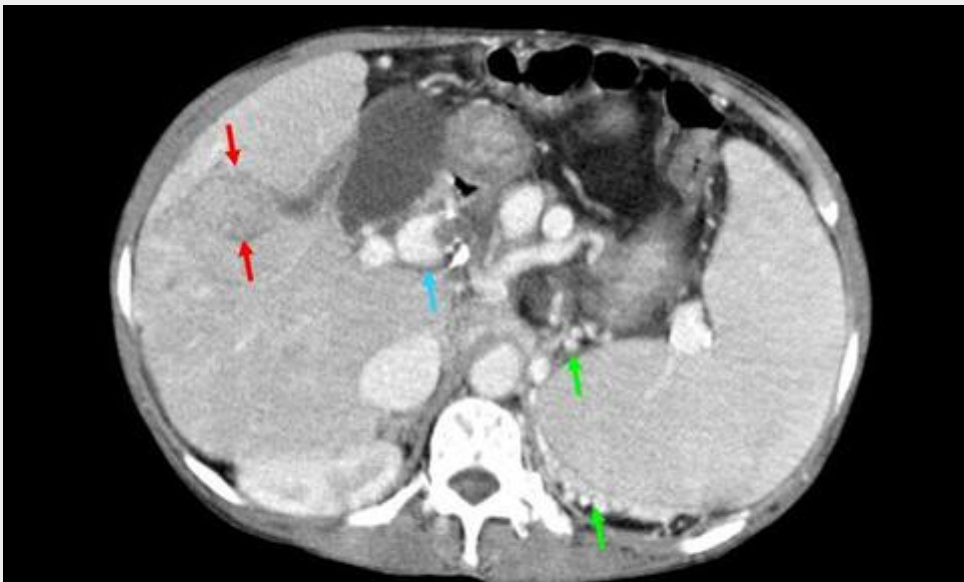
Caroli's Syndrome. Post-contrast abdominal CT depicting the dilated intra-hepatic bile duct filled with calculi (→). Note the splenomegaly, dilation of the portal vein (→) and perisplenic varicosities (→).
